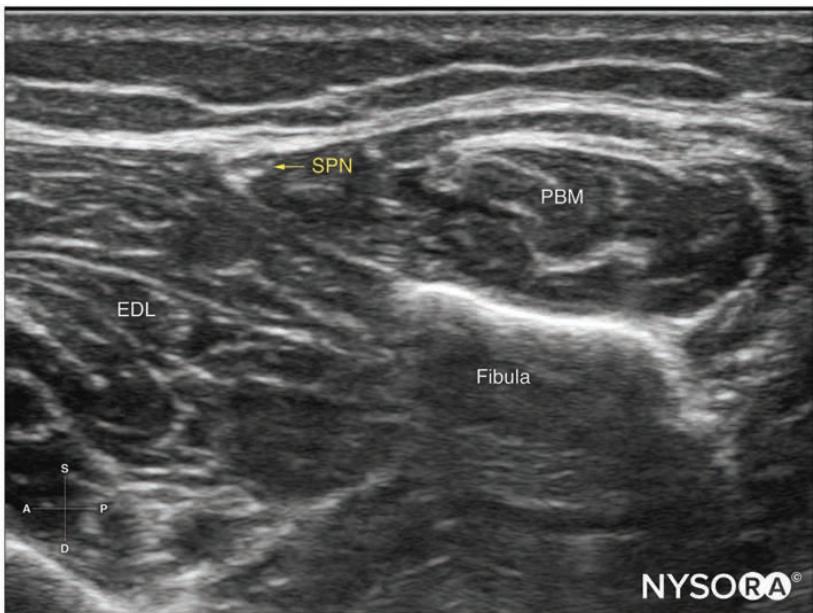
Transducer position and ultrasound anatomy to block the superficial peroneal nerve. EDL, extensor digitorum longus; SPN, superficial peroneal nerve; PBM, peroneus brevis muscle.
